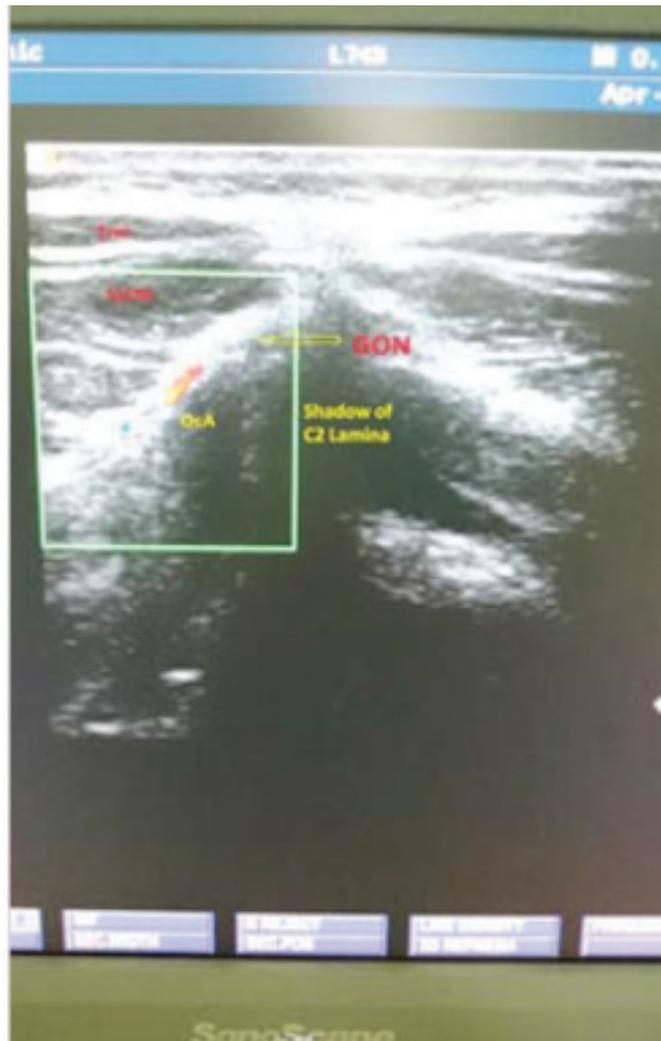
Sonographic picture of occipital artery and greater occipital nerve
